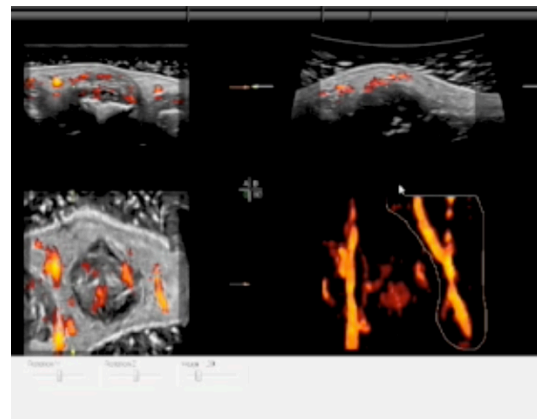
Quantification of 3D Power Doppler volume data set
